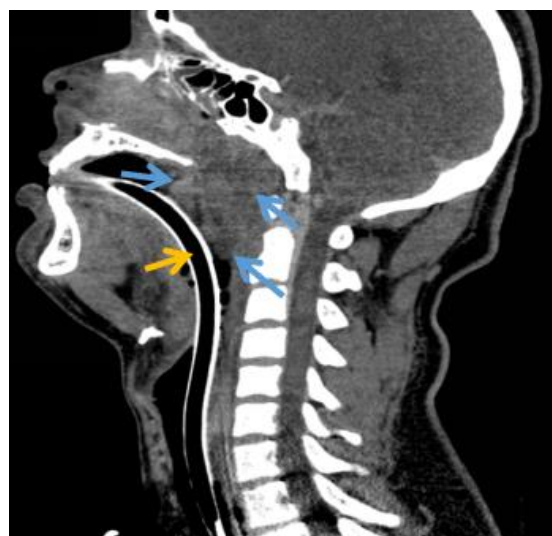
Sagittal CT scan of the face and neck with contrast after endotracheal tube placement (orange arrow), with marked diffuse swelling/hyperemia of the adenoid tissue (blue arrows) and severe narrowing of the nasopharyngeal airway.
